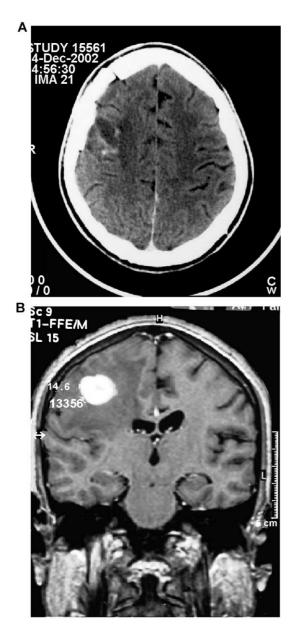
MRI images of the brain of the patient showing a mass lesion with perifocal edema.
